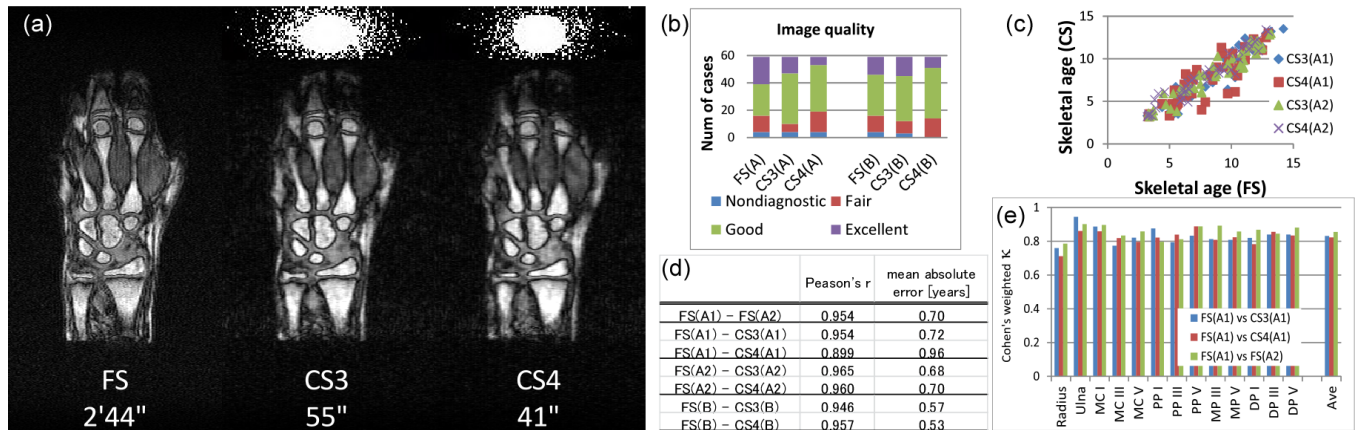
(a) Optimal sampling patterns and examples of MR images acquired with full sampling (FS), and CS with acceleration factor of 3 (CS3) and 4 (CS4). (8.6 years, girl). (b) Image quality evaluation. (c) Comparison of skeletal ages rated from FS and CS images. (d) Pearson's r and mean absolute error between different rating results. (e) Agreement of rating for each RUS bone.
